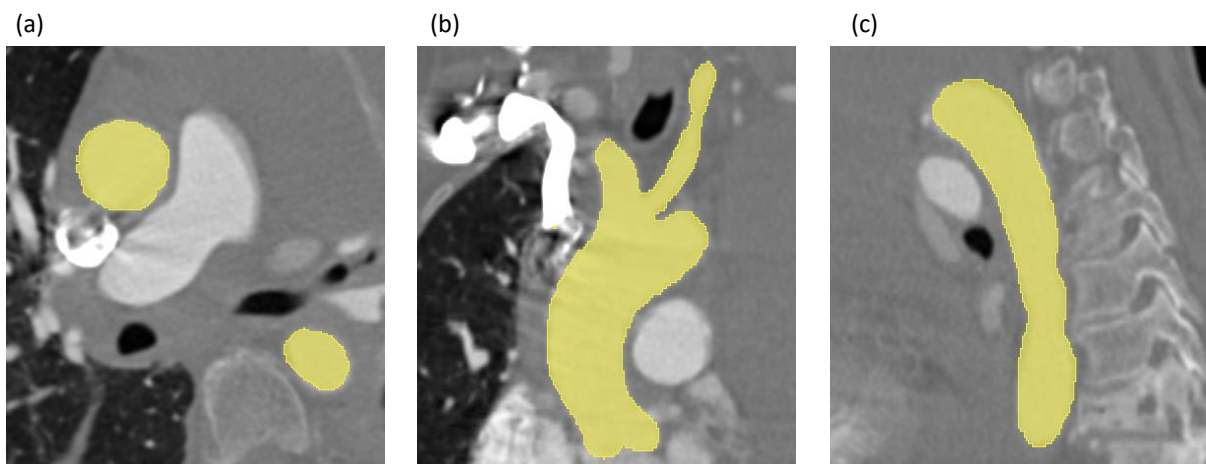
Aortic arch identification on CT Scan slices. (a) CT Scan slice in the horizontal plane. (b) CT Scan slice on the frontal plane. (c) CT Scan slice in the lateral plane.
